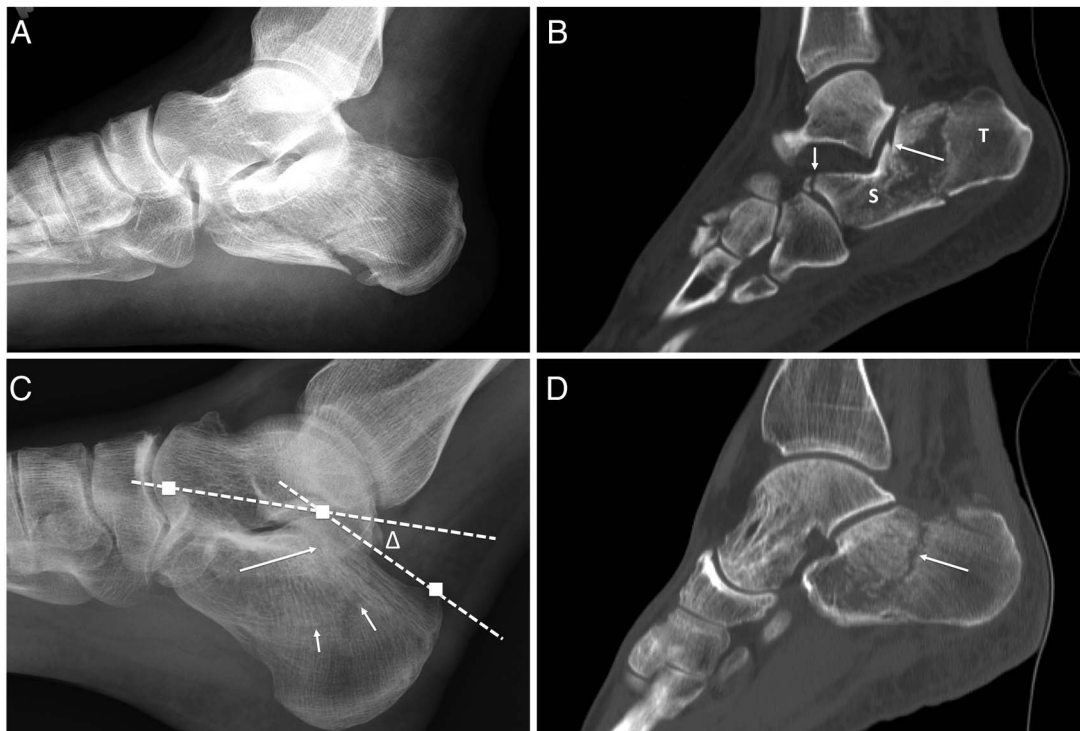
Calcaneal fractures. (A) A 42-year-old man with an acute intra-articular calcaneal fracture on lateral radiograph and (B) sagittal CT. Fracture extends into the posterior calcaneal facet (long arrow). An associated fracture of the anterior calcaneal process is noted (short arrow). T indicates the tuberosity fragment while S indicates the sustentacular fragment. (C) A 56-year-old woman with a much more subtle acute intra-articular calcaneal fracture. Lateral radiograph shows subtle trabecular disruption with linear lucency (short arrows), compatible with acute fracture. Fracture was suspected to extend into the posterior facet (long arrow). Bohler's angle is the theoretical angle created by lines connecting the highest points of the anterior and posterior calcaneus on the lateral view (these points are shown as white squares); it is the angle created by the dashed lines (Δ) and is normally between 20° and 40° , as in this case. It may be, but is not always, decreased in calcaneal fractures. (D) Sagittal CT confirms calcaneal fracture (arrow). Fracture extended into the posterior facet, and nearly to the calcaneocuboid joint (not shown).
